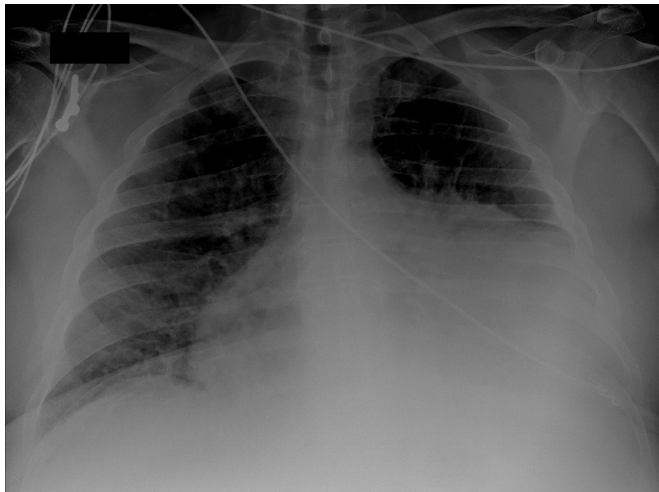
Chest X-ray at admission with increased cardiothoracic index.
